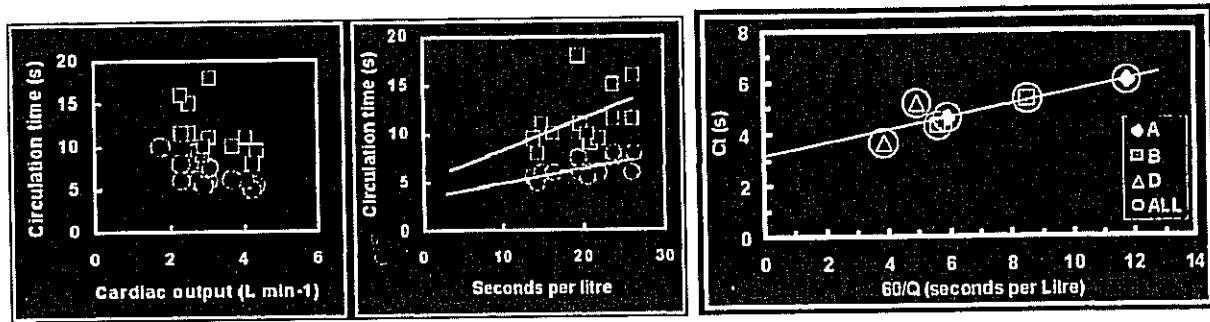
The left and middle panels show individual results for 16 patients referred to nuclear medicine for chest pain. The left plot is of two circulation times (delay between arrival of [1] nuclide at lung and carotid artery and [2] between lung and finger) versus cardiac output (Q_{gs} , gated SPECT estimate). The center panel shows these two circulation times plotted against $60/Q_{gs}$ (with best fit regression lines). Symbols: lung to carotid = \circ ; lung to finger = \square . The right panel shows Ct versus $60/Q_{ir}$ for normal subjects (Q_{ir} estimated from the CO_2 rebreathing method; only available for 3 of the 6 normal subjects, A, B, and D).
